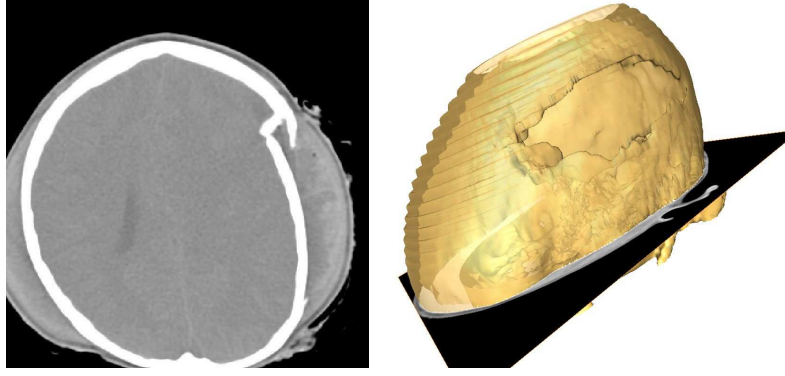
pre-operation situation: (a) CT-image (b) reconstructed surface
